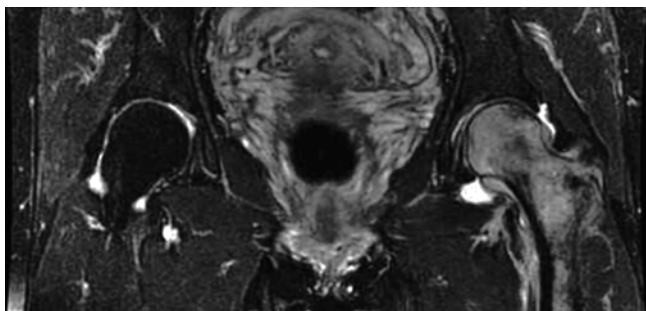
On T2-weighted spin-echo image (TR/TE: 3,337 ms/100 ms), the lesion changes to a high-signal intensity
